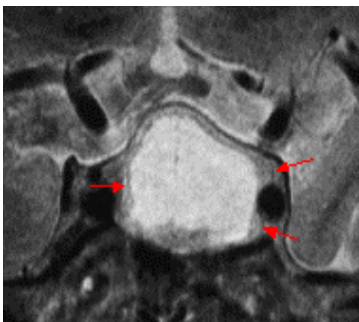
T2-weighted RARE 3T MR image: Cystic pituitary macroadenoma. Right sided infiltration of cavernous sinus (arrow) as confirmed by surgical findings, left sided delineation of medial cavernous sinus border by a hypointense line (2 long arrows).
